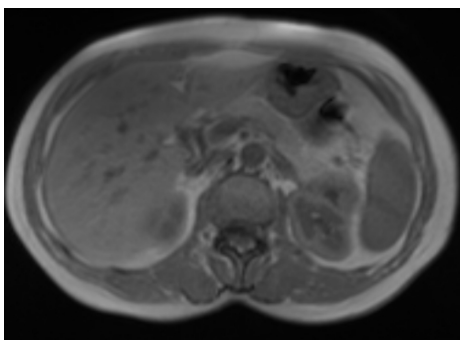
In phase (Contrast-enhanced abdominal magnetic resonance images of the patient)
